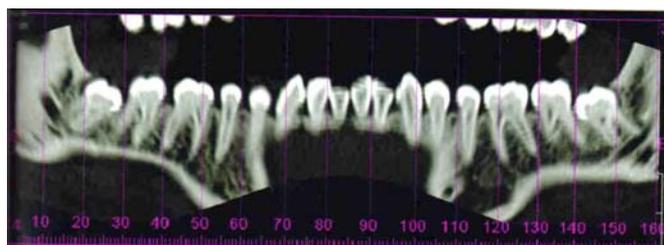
Panoramic view of CT scan showing bilaterally impacted mandibular third molar
